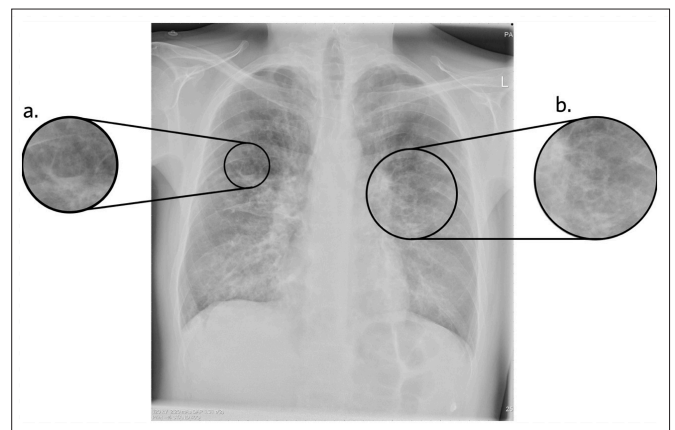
Chest radiograph showing increasing bronchovascular markings. Bronchial fluid level (a), and ring shadows (b) outlined and magnified.
